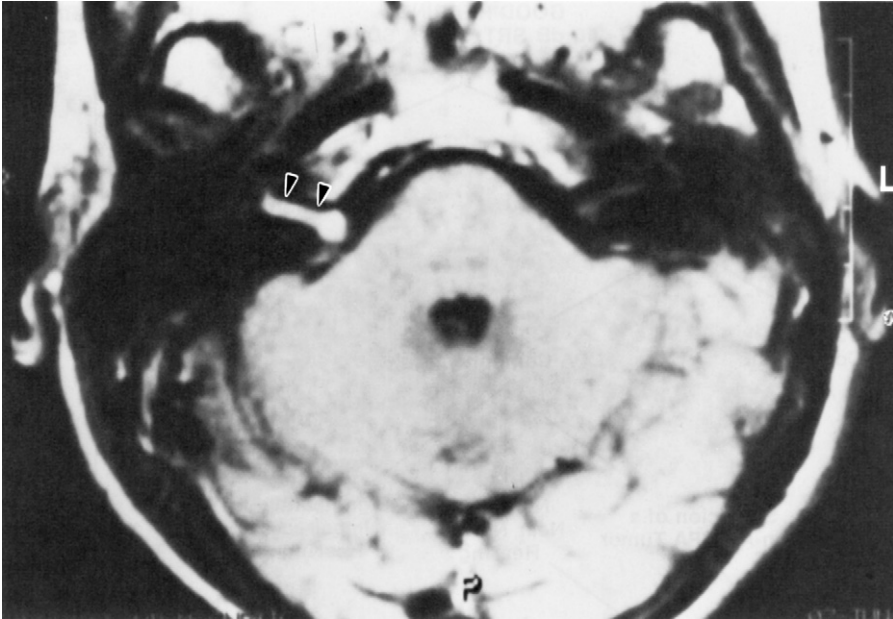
Deep involvement of the internal auditory canal (*arrowheads*) by a small acoustic neuroma but only a small cisternal component as seen on an axial gadolinium-enhanced T₁ magnetic resonance imaging scan. It is difficult to save hearing with such a lesion with the suboccipital approach because exposure of the tumor requires drilling away a portion of the inner ear.
